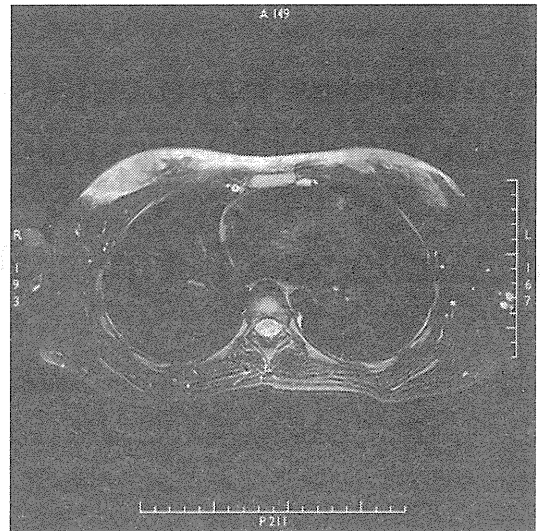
Magnetic resonance imaging of the chest (T2-weighted). The subcutaneous tumor of the chest wall showed high signal intensity.
